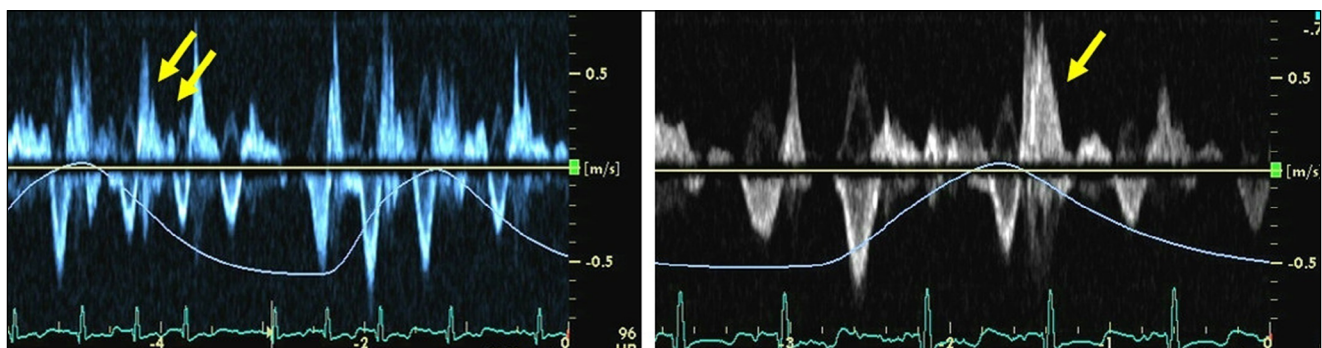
Hepatic vein Doppler in a patient with constrictive pericarditis and atrial fibrillation at baseline (left) and after cardioversion (right). Due to rapid heart rate, expiratory hepatic vein flow reversal happens during systole (arrows, left). Few hours later after cardioversion to sinus rhythm, repeat Doppler echocardiogram shows a prominent expiratory flow reversals during diastole (arrow, right).
